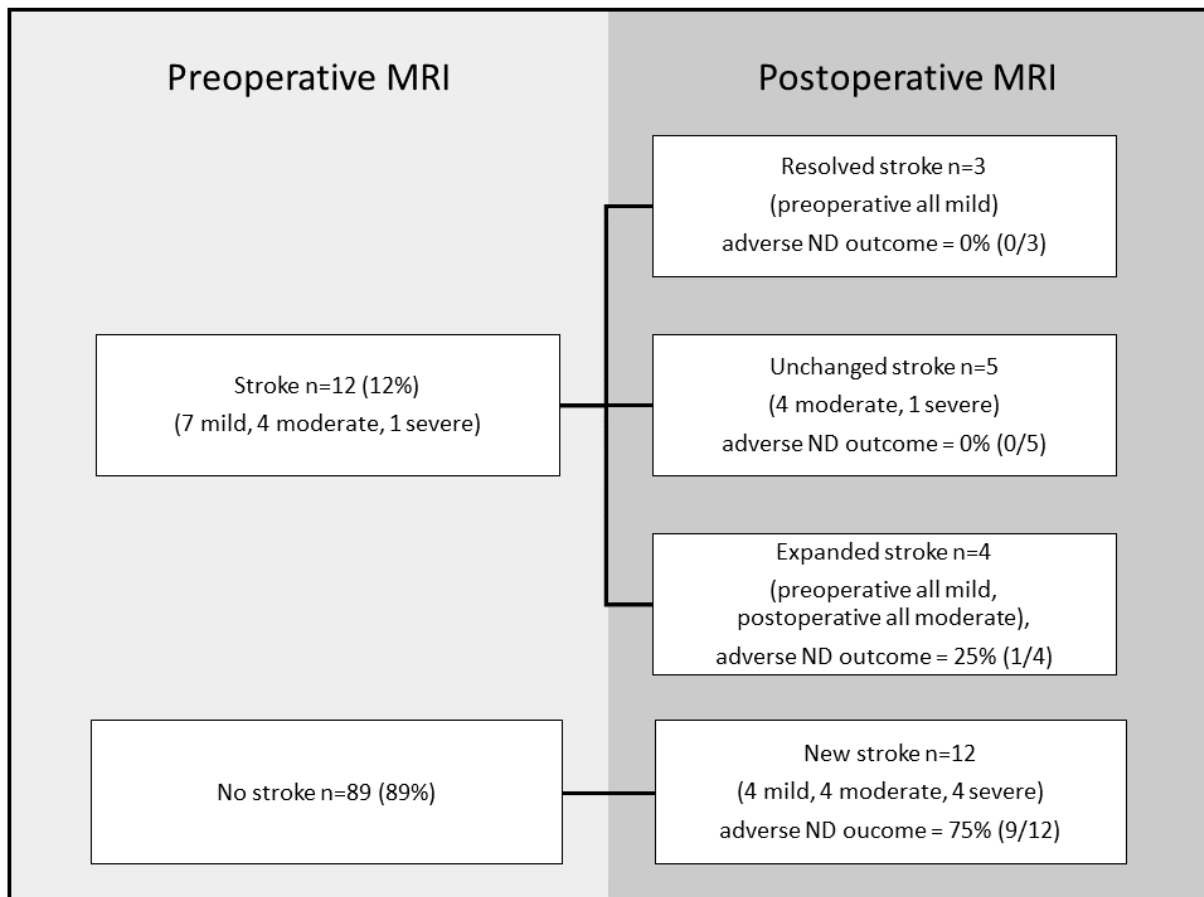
ND outcome by stroke time and severity (includes only patients with ND assessment). Mild: less than 1/3 of vascular territory of anterior/middle/posterior cerebral artery in 1 hemisphere, total size 1 to 5 mm. Moderate: 1/3 to 2/3 of vascular territory, total size 6 to 15 mm. Severe: greater than 2/3 of vascular territory, total size greater than 15 mm. MRI, magnetic resonance imaging; ND, neurodevelopmental.
